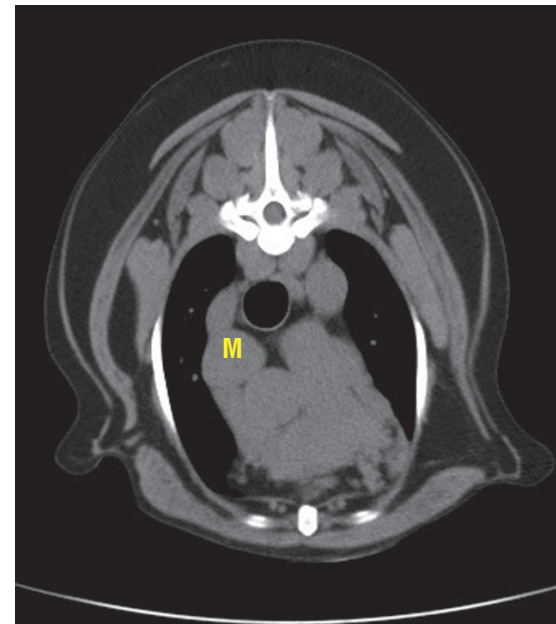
CT image showing mediastinal lymph node metastasis of anal sac adenocarcinoma marked 'M'.
